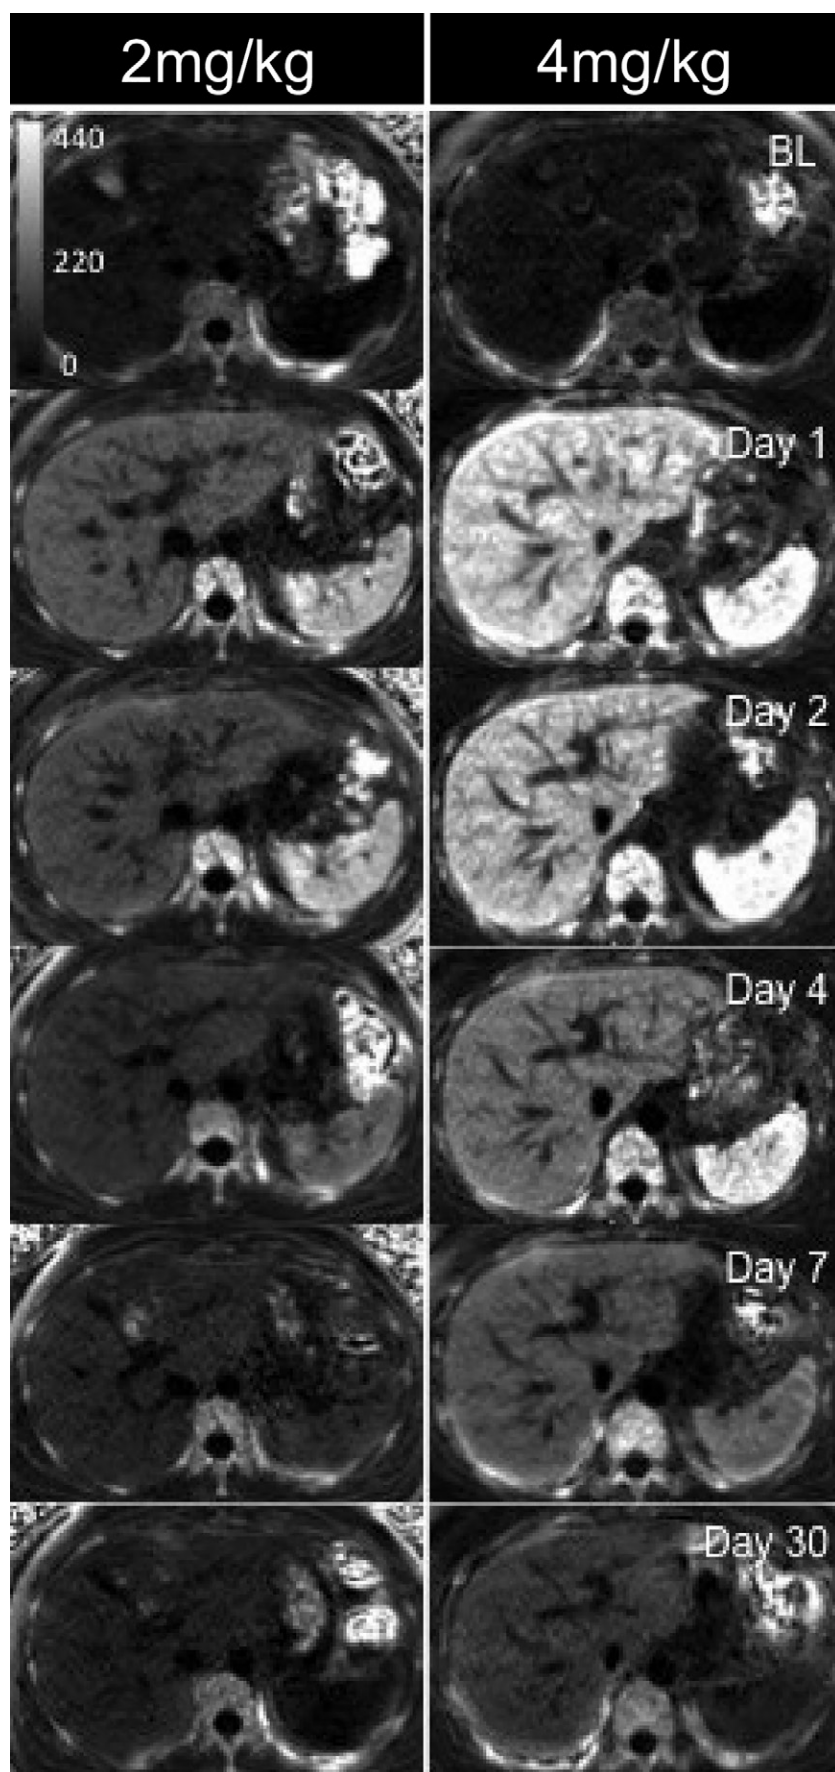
R2* maps of the abdomen in a volunteer who received 2 mg/kg ferumoxytol (FE) (left) and a volunteer who received 4 mg/kg FE (right) show biodistribution and clearance of FE in mononuclear phagocyte system organs (liver, spleen, and bone marrow) at 1.5-T MRI at baseline (BL) and across visits (days 1, 2, 4, 7, and 30). Window level was set to 220 sec⁻¹, and window width was set to 440 sec⁻¹ for all images.
